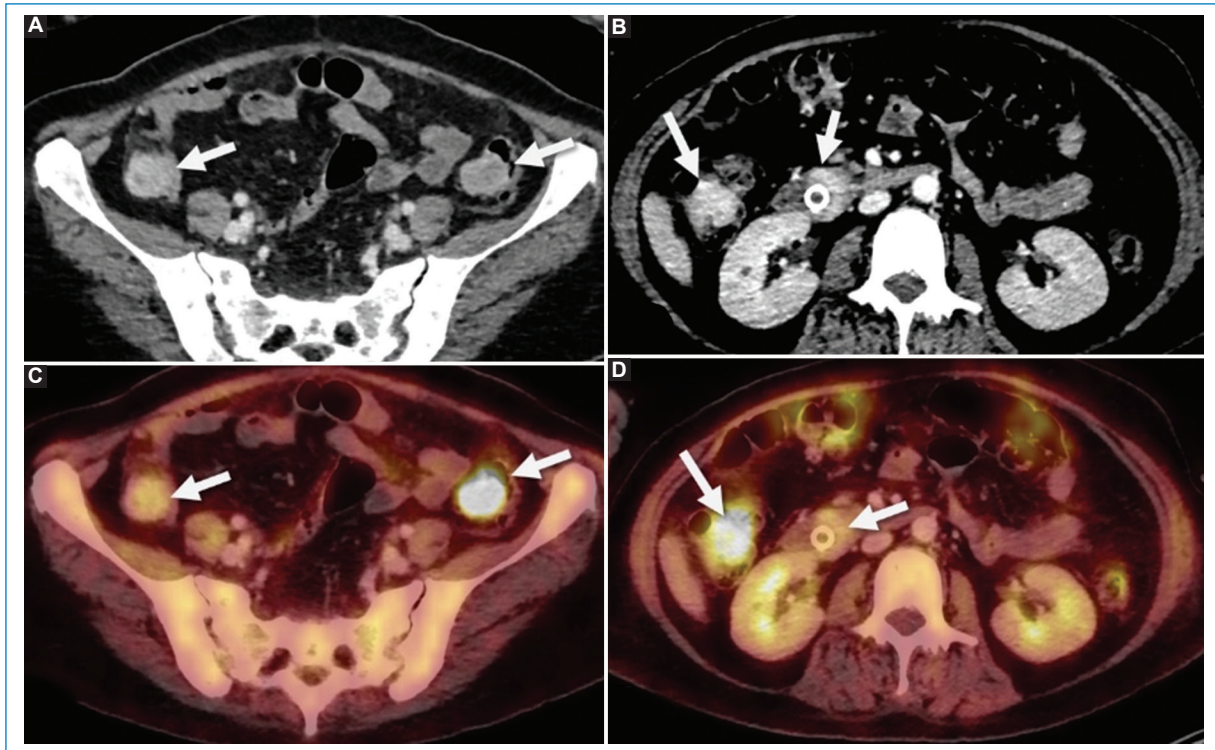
Contrasted CT in venous phase and FDG PET/CT axial fusion of the pelvis and abdomen that shows multiple solid, round, well-defined focal lesions with homogeneous enhancement in the peritoneum of the right iliac fossa and in the serosa of the descending colon in the left iliac fossa (arrows in A and B), a polypoid lesion in the hepatic flexure of the colon and another lesion in the duodenal papilla with a biliary *stent* (arrows in C and D), with different affinity for FDG, compatible with extramedullary plasmacytomas.
